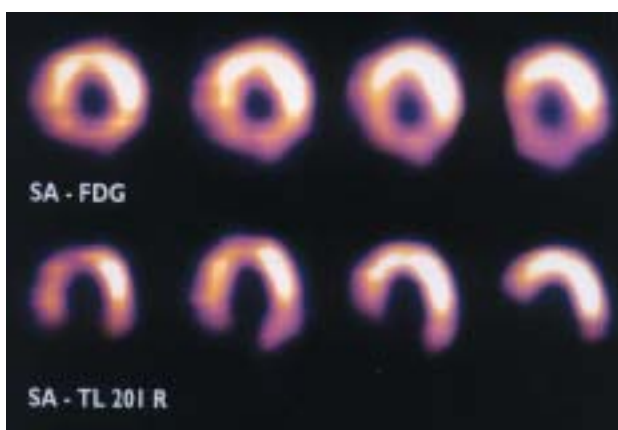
Short-axis views of glucose uptake (FDG) and resting perfusion (resting thallium-201) in a patient with left ventricular dysfunction. Depicted are mid-ventricular short-axis slices with the anterior wall at the top, the lateral wall on the right, the inferior wall at the bottom, and the septum on the left. A clear FDG mismatch (increased FDG relative to perfusion) is observed in the septal and inferior area. Reproduced from reference 15 with permission.
